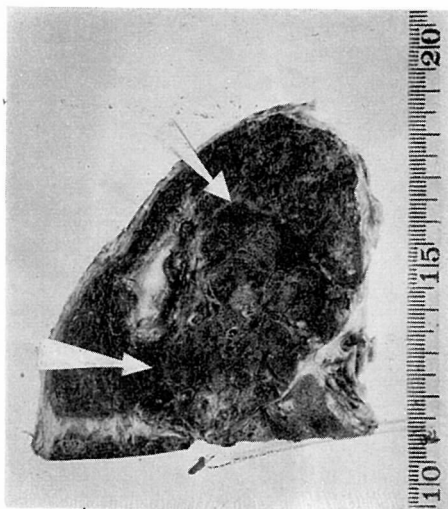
Cut surface of the part corresponding to the roentgenogram of fig. 1. Lateral parts (arrows) show silicotic callosity, and the interior is emphysematous.
